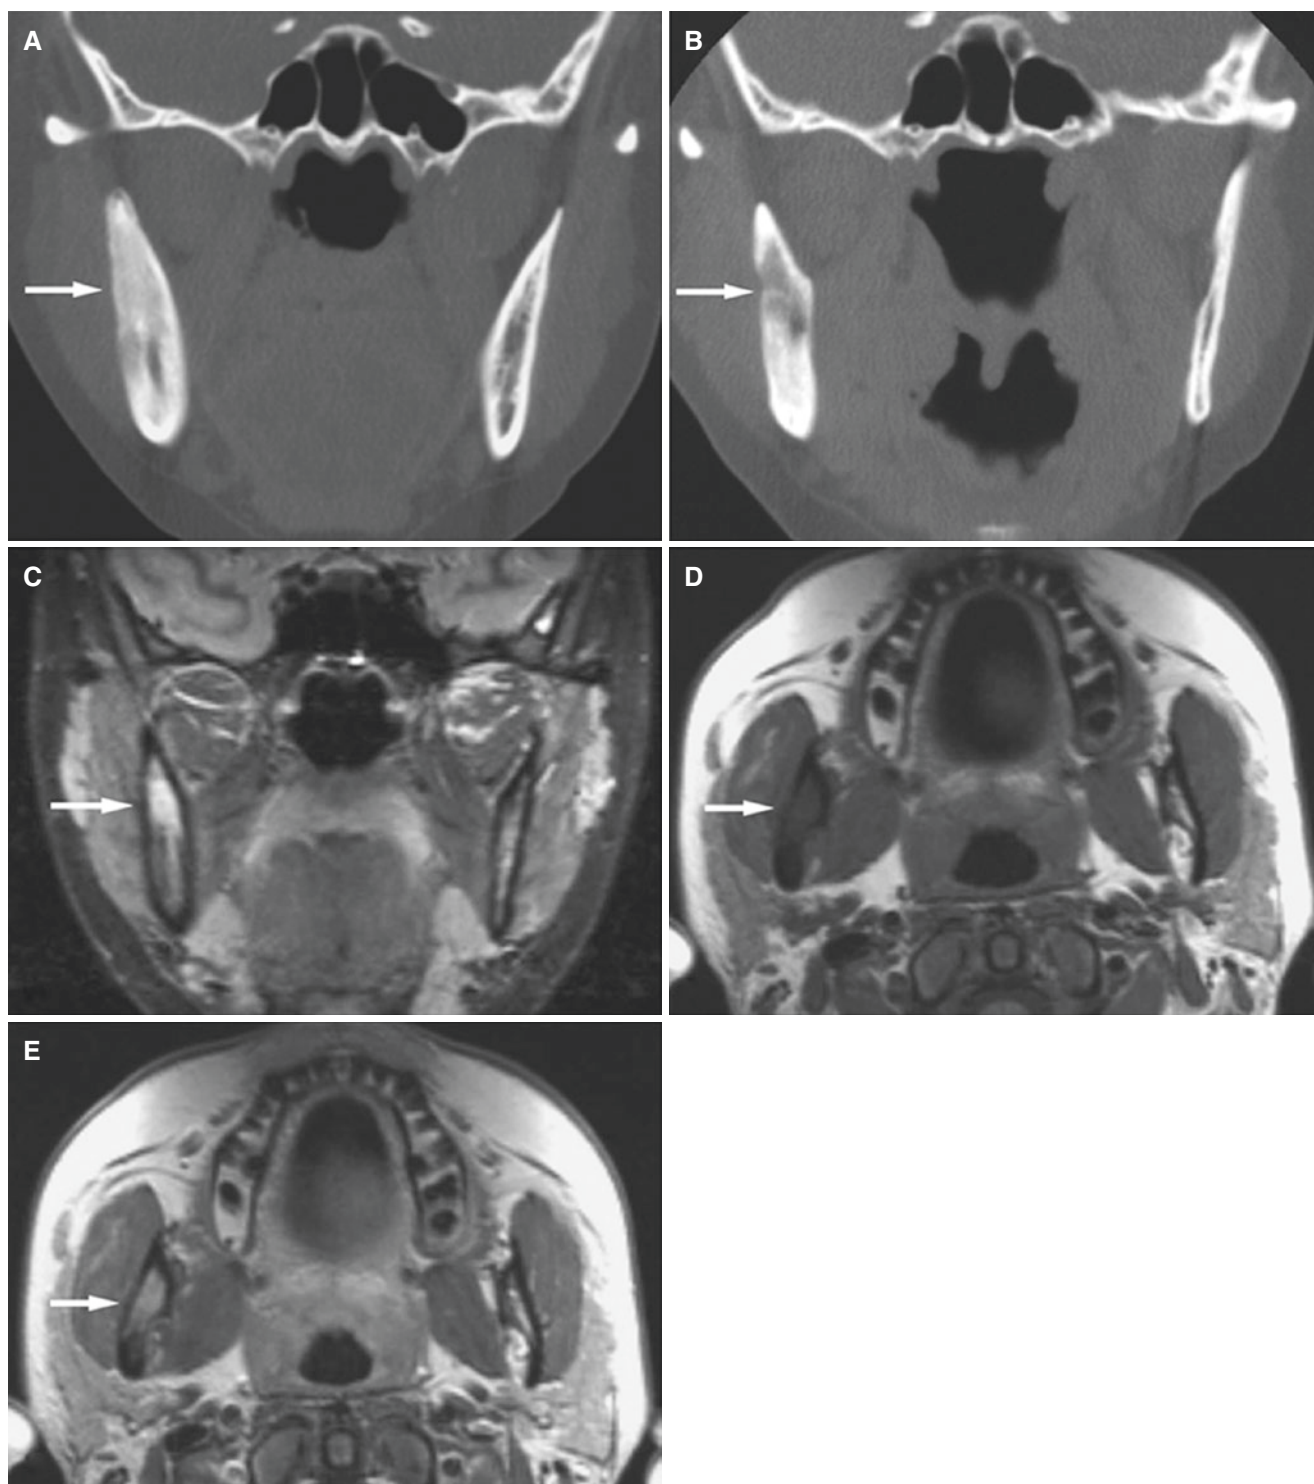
Osteomyelitis with periostitis, mandible; 25-year-old female with a 4-year history of infection; after a 3-year period of silence because of antibiotic and hyperbaric oxygenic treatment, now with pain in the right cheek. (A) Coronal CT image shows sclerotic, thickened ramus (*arrow*). At 3-year follow-up, (B) coronal CT shows area of bone
